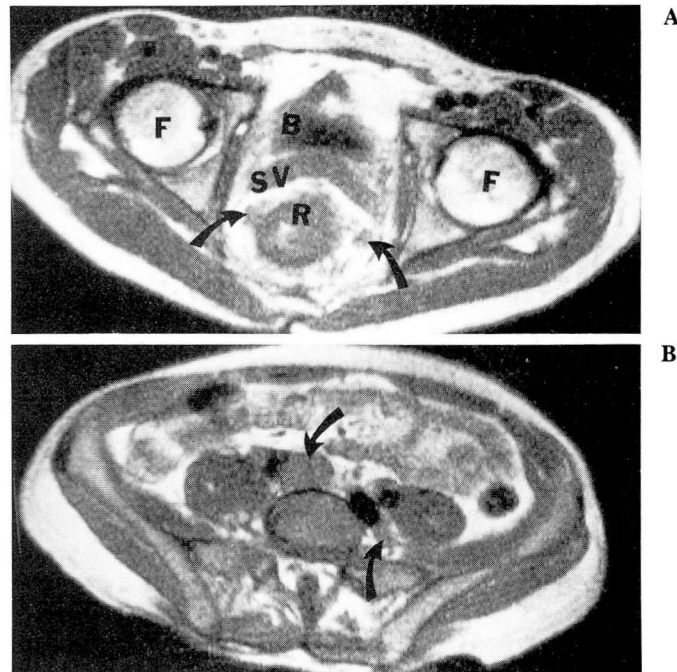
A. Transverse magnetic resonance scan at the level of the femoral heads (F) (approximately the same level as the CT scan [Fig. 2]). The bladder, seminal vesicles, and the thickened rectal wall can be identified. Note the similar configuration of densities invading the pararectal fat, resembling that seen in Figure 2.
